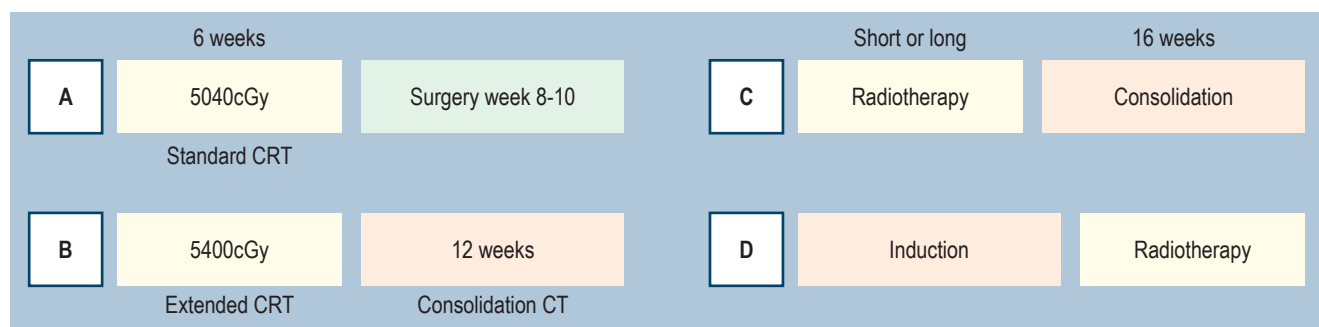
A. Standard CRT. B. Extended CRT, Brazil. C. TNT, Consolidation chemotherapy. D. TNT, Induction chemotherapy. CT: chemotherapy; CRT: chemoradiotherapy. Source: Scheme made by authors.
